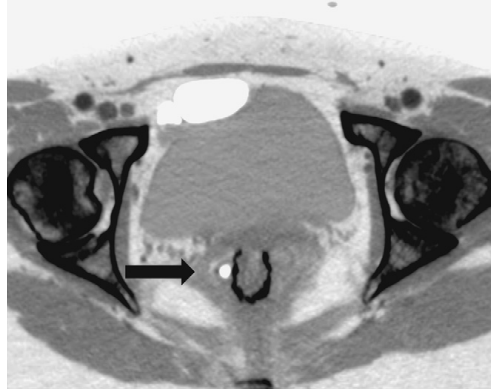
Computed tomography, axial view, shows marked thickening of the presacral space consistent with an anastomotic leak (arrow).
